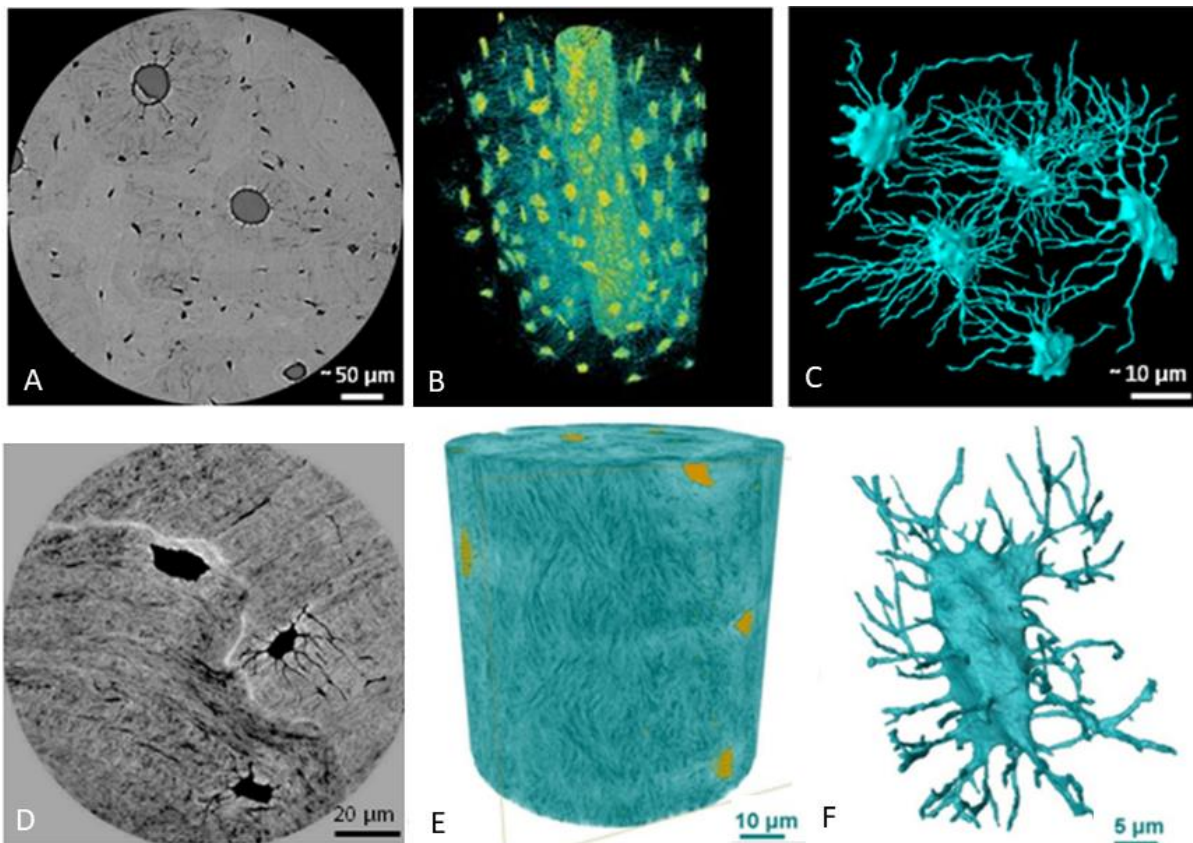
Synchrotron radiation computed tomography images of human femur.
